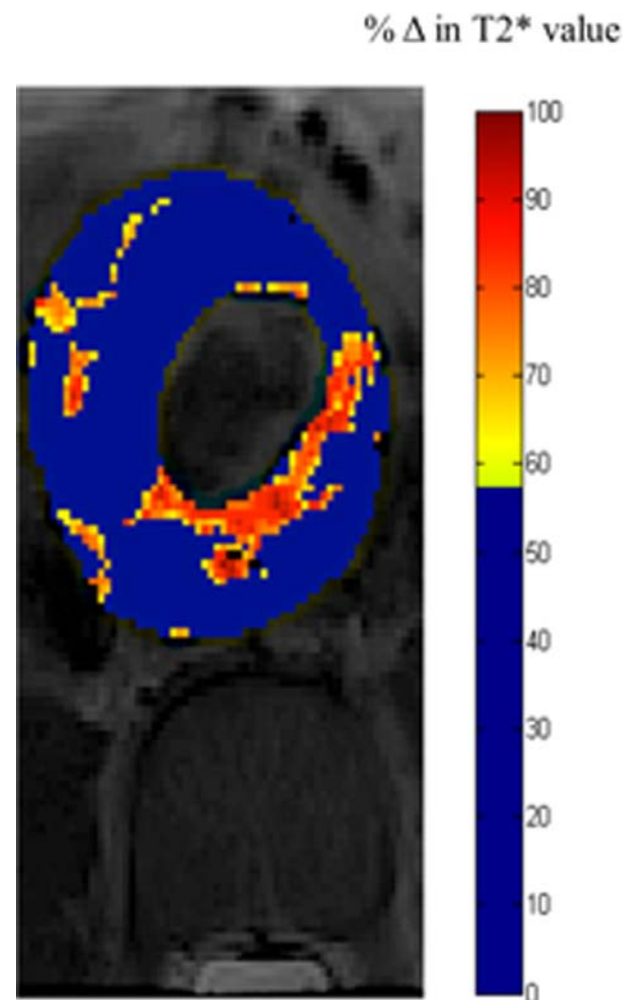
Colour map of MRI of an abdominal aortic aneurysm. Red and yellow pixels indicate areas of increased T2* value, indicative of ultrasmall superparamagnetic particles of iron oxide uptake.
